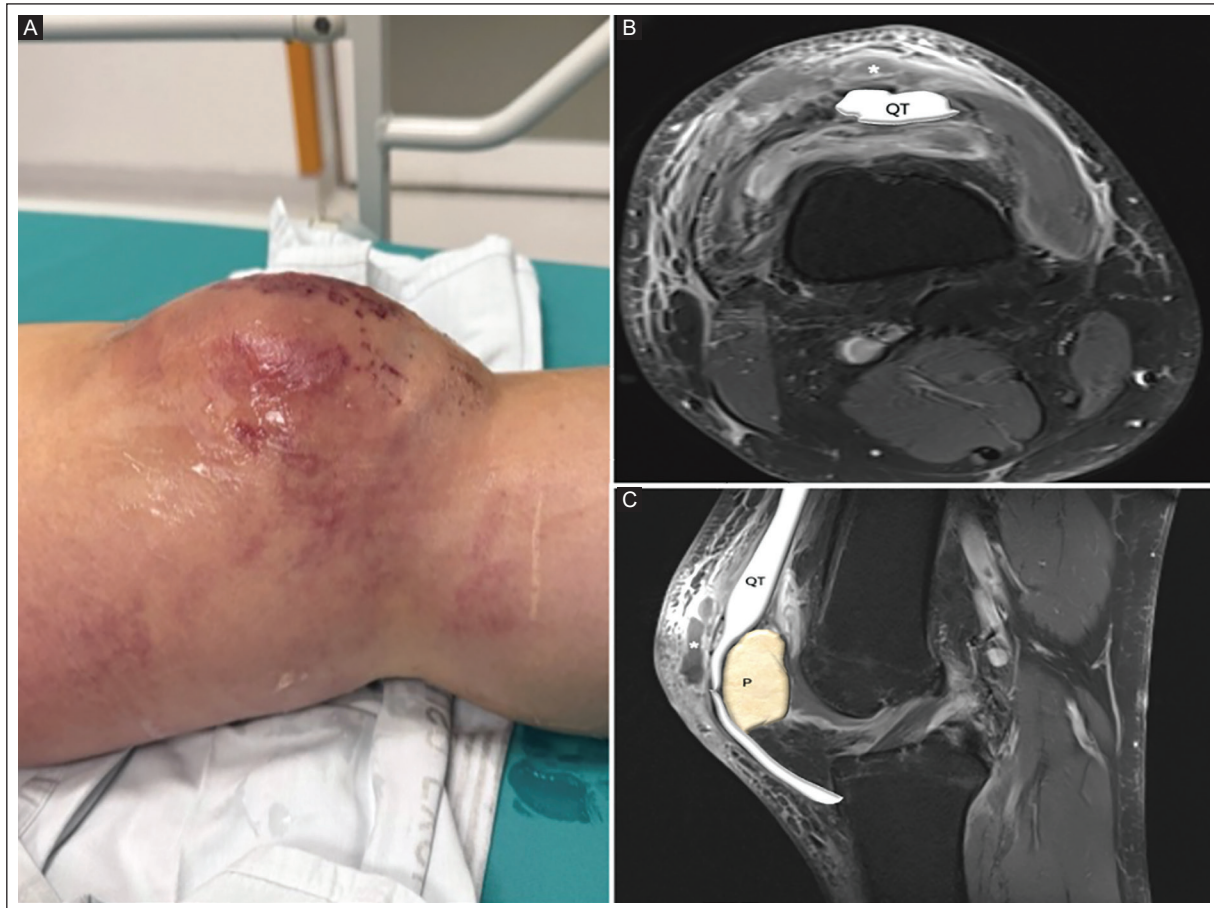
A: clinical photograph of the left knee in a 53-year-old man shows marked edema, erythema, and superficial skin abrasions over the anterior aspect of the knee, suggestive of septic prepatellar bursitis, commonly caused by direct inoculation through skin disruption. B: axial T1-weighted fat-suppressed post-contrast knee MRI shows a hypointense fluid collection in the superficial prepatellar bursa (asterisk) with peripheral bursal wall enhancement and a hyperintense anterior subcutaneous edema. C: axial T1-weighted fat-suppressed post-contrast knee MRI shows a hypointense fluid collection in the superficial prepatellar bursa (asterisk) with peripheral bursal wall enhancement and hyperintense anterior subcutaneous edema.
